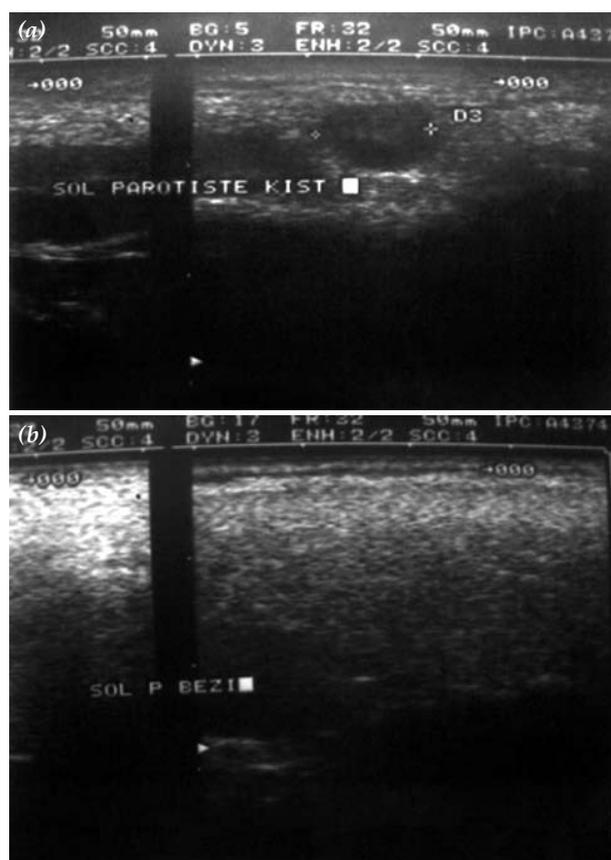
(a) Ultrasonographic appearance of a 10x8-mm hypoechoic mass located in the pretragal area. (b) The mass disappeared after a week.
